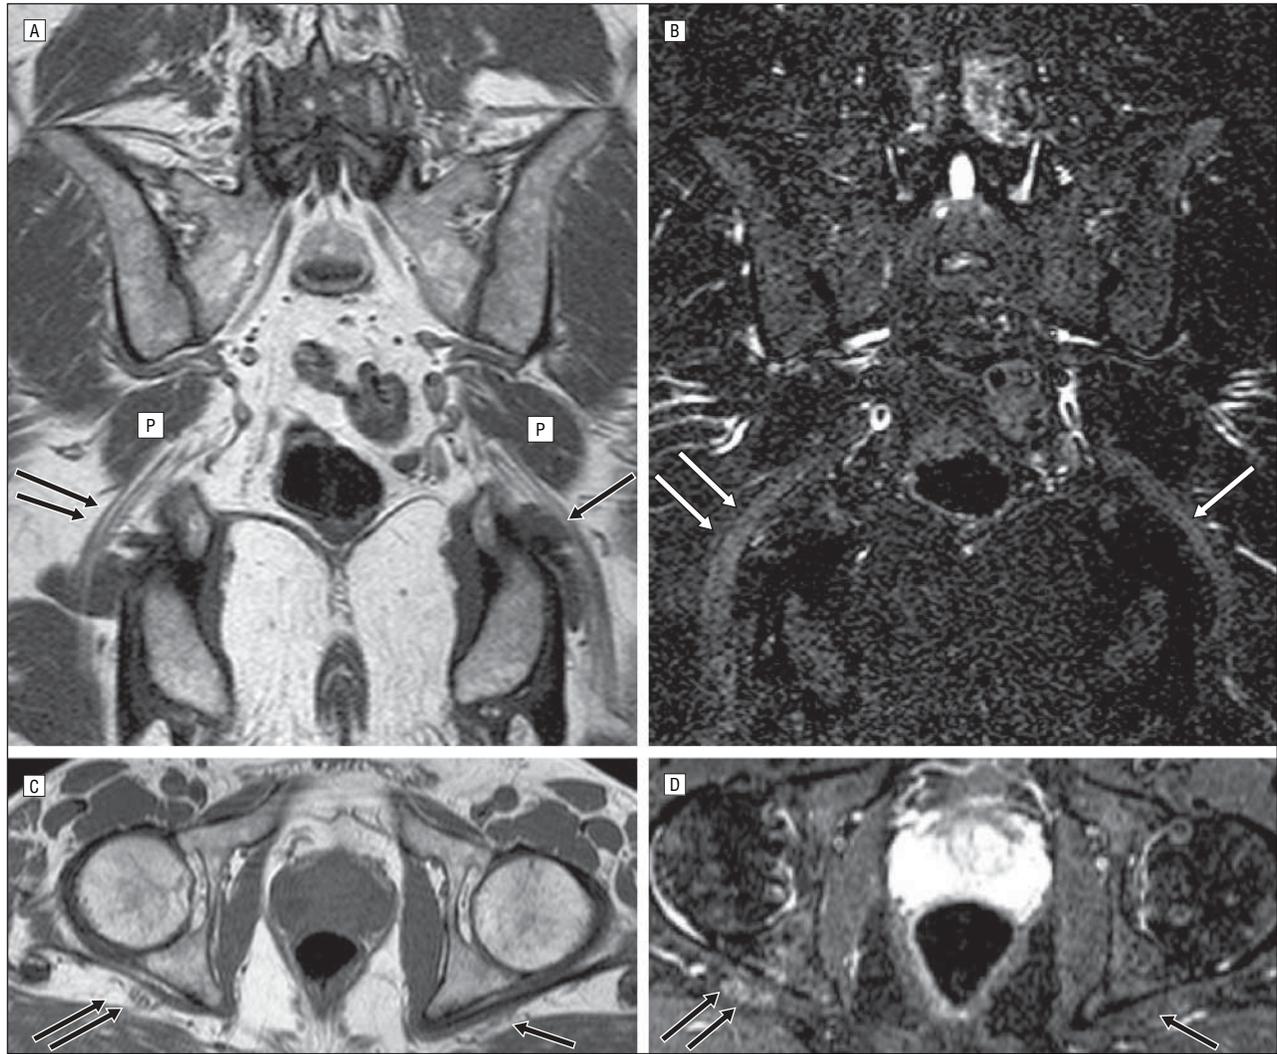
Coronal and axial T1-weighted (A and C) and short tau inversion recovery (STIR) (B and D) sequences through the lumbosacral plexus and sciatic nerves bilaterally. A and C, The anatomical T1-weighted sequences demonstrate the course of the sciatic nerves (double arrows and single arrows) exiting the sciatic notch beneath the piriformis muscles (P). B and D, The STIR sequences demonstrate the right sciatic nerve (double arrows) to be larger and higher in signal compared with the left sciatic nerve (single arrows) as it exits the sciatic notch.
